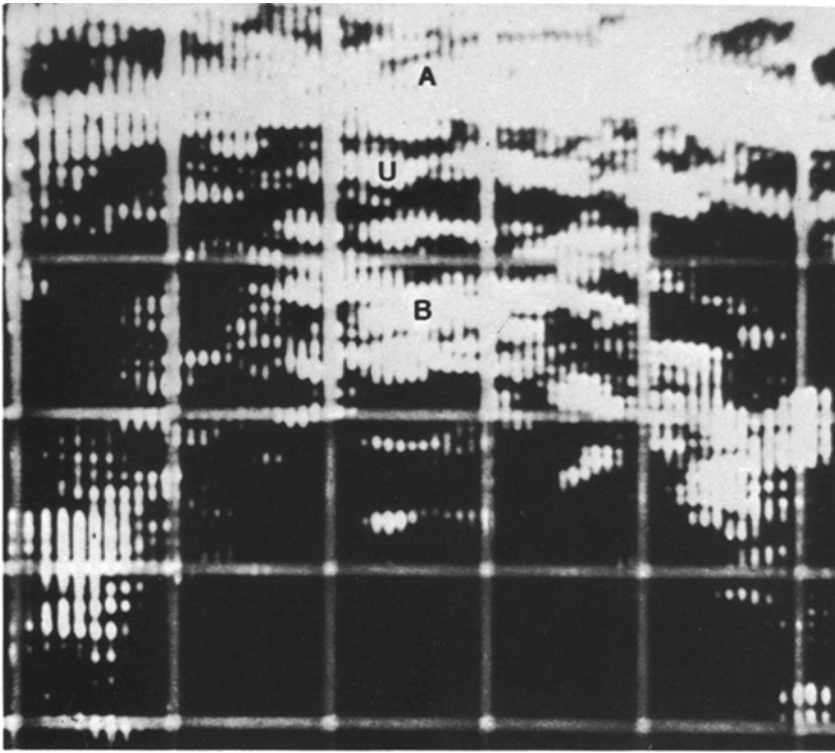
Ultrasound real time display (Vidoson) showing fetal skull with open contour lines in suprapubic transverse body scan. *A*, abdominal wall; *U*, uterine wall; *B*, fetal skull base
